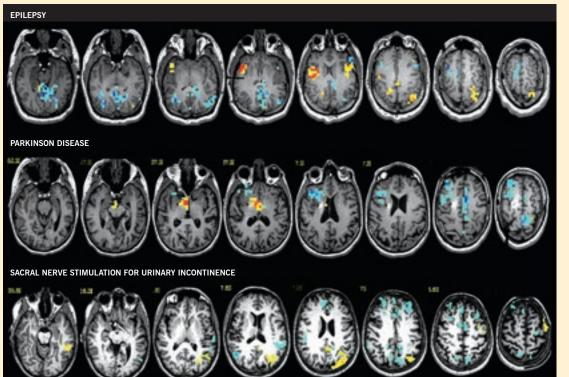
Functional MRI activation maps during intracranial stimulation of a patient with epilepsy (top row), deep brain stimulation of a patient with Parkinson disease (middle row) and sacral nerve stimulation of a patient with urinary urgency incontinence (bottom row). In all cases. stimulation of an electrode in neural tissue evoked a response in distal areas of the brain. These patterns reveal much about underlying brain networks. The study, diagnosis and manipulation of brain networks represents the next frontier for neurological therapies.
